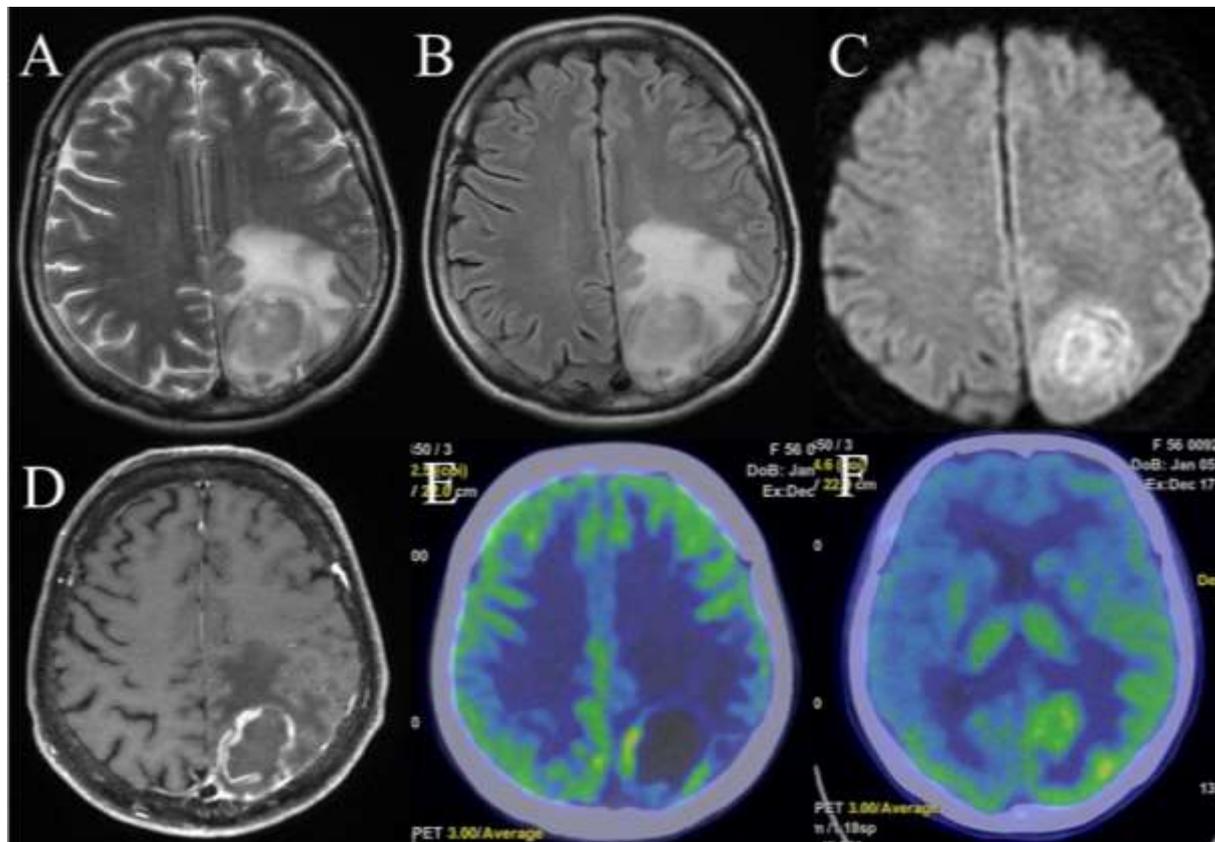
The radiographic image of the head is presented below. The magnetic resonance imaging are shown below. T2-weighted (A), fluid-attenuated inversion recovery (B), diffusion-weighted image (C), and gadolinium-contrast T1-weighted (D). The positron emission tomography (PET) scans of the head with 5-fluorodeoxyglucose (E) and methionine (F) are displayed below.
